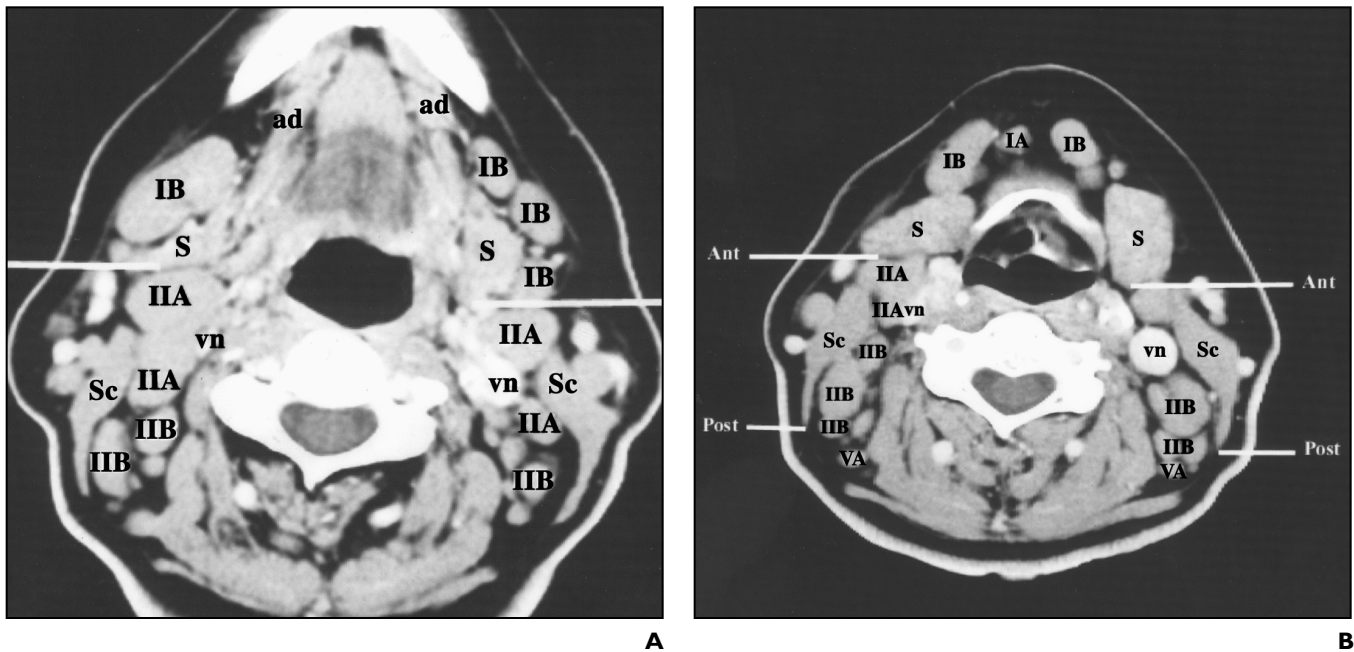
44-year-old man with lymphoma. ad = anterior belly of digastric muscle, S = submandibular gland, vn = internal jugular vein, Sc = sternocleidomastoid muscle. A, Axial contrast-enhanced CT scan of neck through floor of mouth and above level of hyoid bone. White line is drawn through back of each submandibular gland. Nodes anterior to lines are level I nodes and, because they are lateral to medial margin of each anterior belly of the digastric muscle, they can be subclassified as level IB nodes. Level II nodes are posterior to white lines, but anterior to posterior edge of sternocleidomastoid muscle. Level II nodes, either anterior to the internal jugular vein or posterior to it but touching it, are subclassified as level IIA nodes. Nodes posterior to internal jugular vein and not touching it are subclassified as level IIB nodes. B, Axial contrast-enhanced CT scan of neck through floor of mouth and at level of hyoid bone. Because level is cranial to that of bottom of body of hyoid bone, internal jugular nodes are classified as level II, not level III. On each side of neck, transverse white line (Ant) has been drawn through posterior edge of each submandibular gland. Second white line (Post) has been drawn through posterior edge of each sternocleidomastoid muscle. Nodes anterior to line (Ant) are level I nodes. Nodes between line (Ant) and line (Post) are level II nodes. Nodes posterior to line (Post) are level V nodes. Because level V nodes are cranial to level of bottom of body of cricoid cartilage arch, they are subclassified as level VA nodes.
